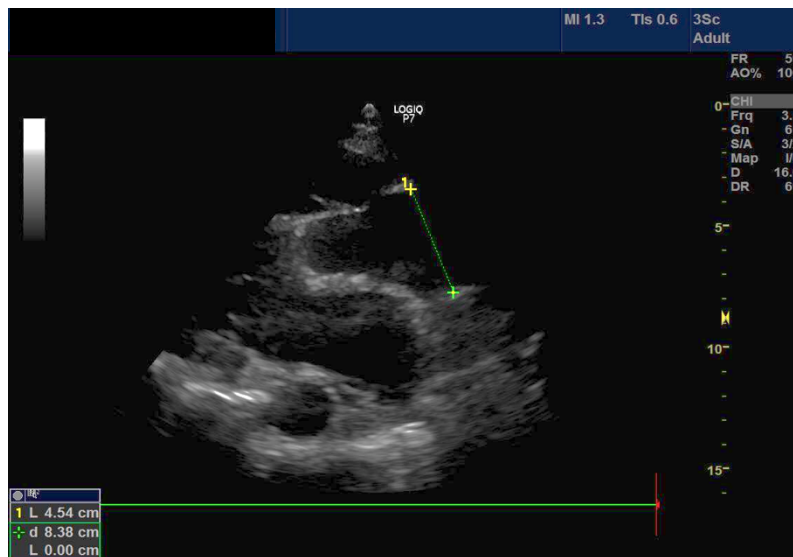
Bedside TTE parasternal long axis view
